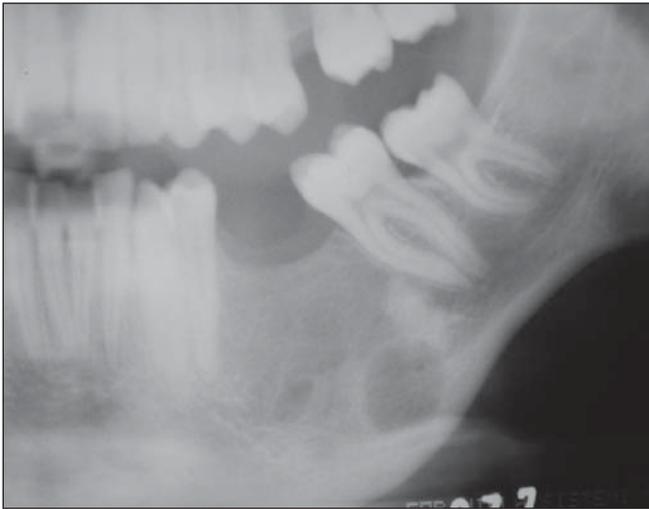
Detail of a panoramic radiograph showing CGCG in the left mandibular corpus, as an unilocular, radiolucent image with well-defined limits.
